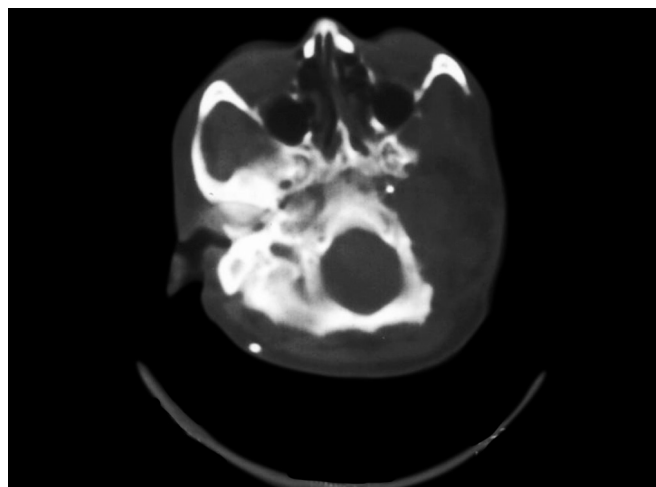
Postoperative computed tomography (CT) scan demonstrating segment of the skull base removed for total temporal bone resection of a 37-year-old woman with osteogenic sarcoma.
